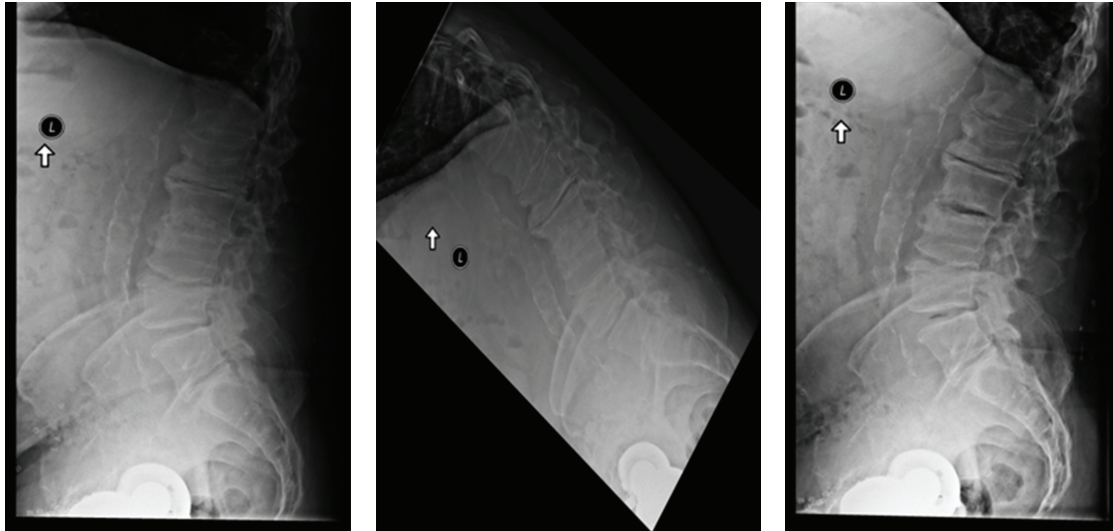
Lumbar X-rays. Standing lateral, flexion, and extension views. Disc degeneration suggested by vacuum disc (on extension) and osteophyte formation.
